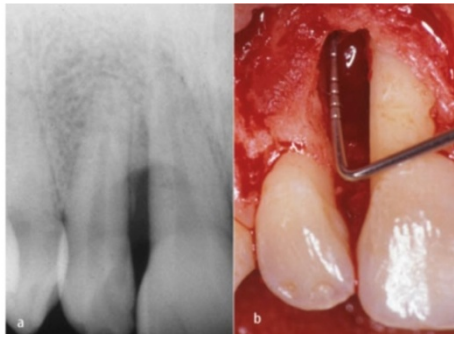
a) radiographic appearance of the involved area, showing radiolucency between central and lateral maxillary right incisors. b) A full thickness flap was elevated. There was a combination of 1, 2, 3 wall osseous defect about 12 mm deep on the distal aspect of the central incisor.
